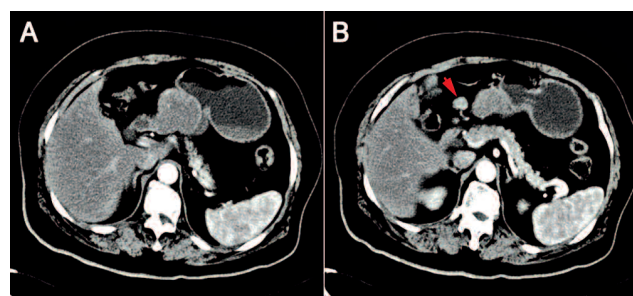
Contrast-enhanced CT showed a well-defined, inhomogeneous, enhanced gastric mass (A) and pathological lymph nodes (B, arrow) adjacent to the lesion.
